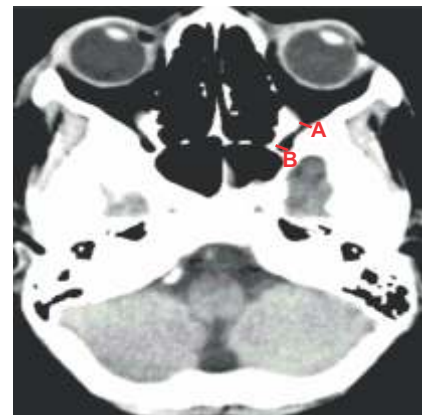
Axial CT slice showing the measurement of the diameter of the orbital (A) and cranial (B) apertures of the optic canal.
